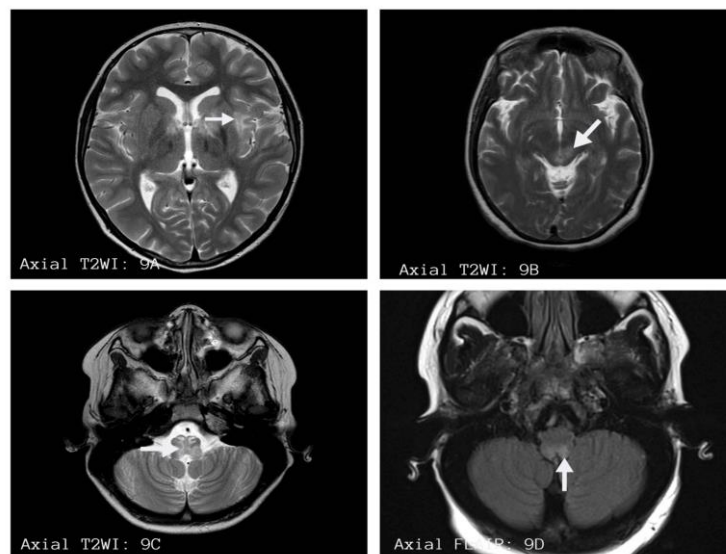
Images of a subject with diagnosed NMSOD showing T2WI hyperintense lesions in external capsule/ periventricular area (9A), periaqueductal grey matter (9B), and medulla oblongata (9C). FLAIR hyperintense lesion of area postrema shown in Figure (9D).
